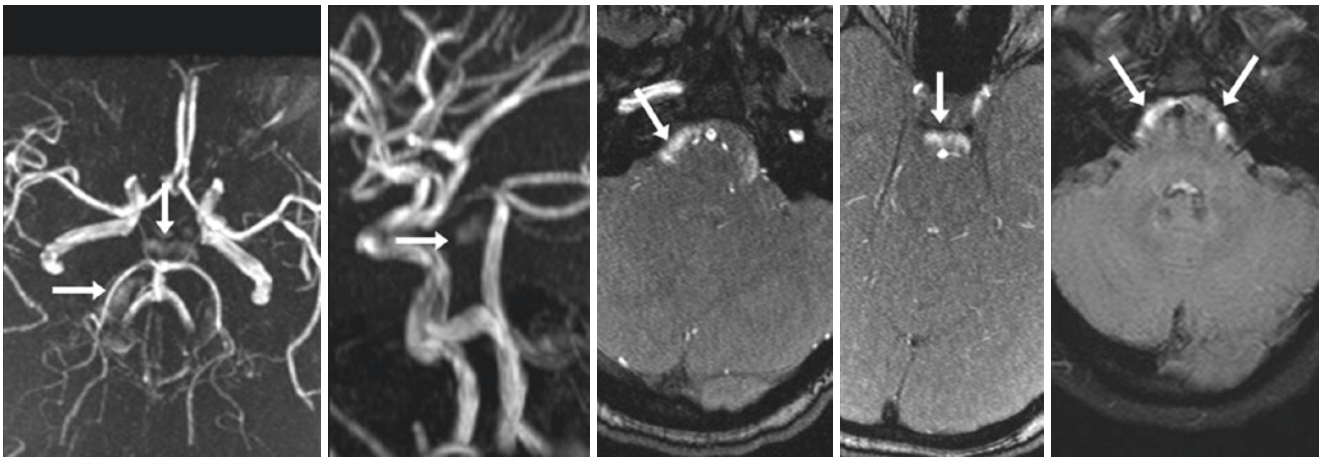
In this 20-year-old, 3D TOF MRA MIP superior (*left*) and lateral (*left middle*) views demonstrate "T1 shine-through" within the basal cisterns (*arrows*), arising from pronounced CSF pulsation artifact surrounding the brainstem. This appearance is confirmed by the axial source images for the MRA (*middle, right middle*), and on FLAIR MRI (*right*)
